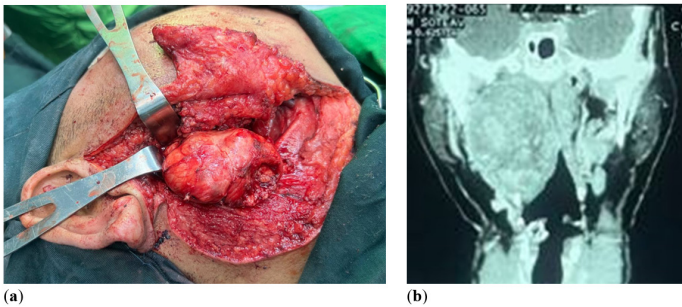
(a) Intraoperative tumor; (b) coronal view of CT scan homogeneously enhancing mass measuring 74 × 50 × 42 mm.
